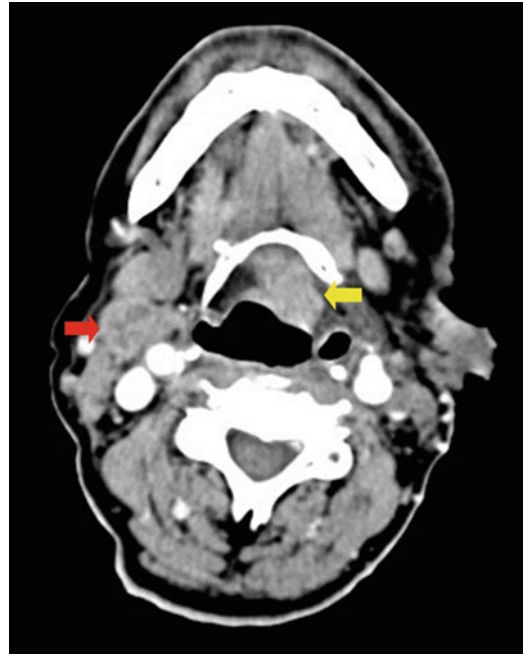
Contrast-enhanced CT neck axial image showing tumor involvement of the pre-epiglottic space (yellow arrow) and necrotic level II lymph node (red arrow)
